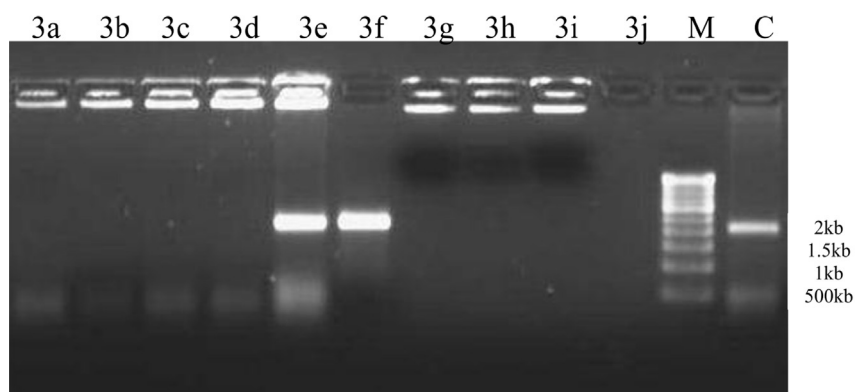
CT-DNA cleavage study using agarose gel electrophoresis. Lane M: standard DNA marker, Lane C: control DNA (untreated sample), Lane 3a: DNA + 3a, Lane 3b: DNA + 3b, Lane 3c: DNA + 3c, Lane 3d: DNA + 3d, Lane 3e: DNA + 3e, Lane 3f: DNA + 3f, Lane 3g: DNA + 3g, Lane 3h: DNA + 3h, Lane 3i: DNA + 3i, Lane 3j: DNA + 3j.
